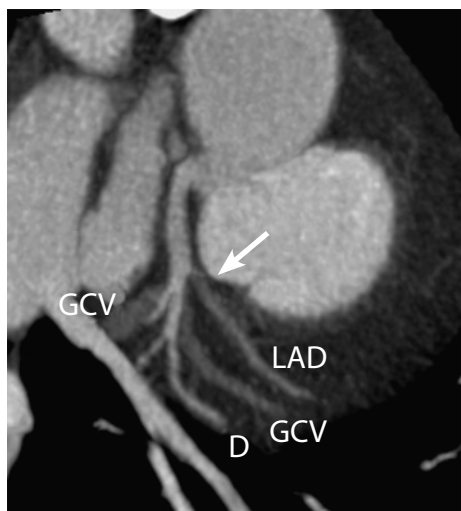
LAD occlusion examined with 16-slice CT. Complete occlusion (*arrow*) of a small LAD, without any other visible plaque or calcium. The large diagonal branch (*D*) with the great cardiac vein (GCV) crosses underneath
